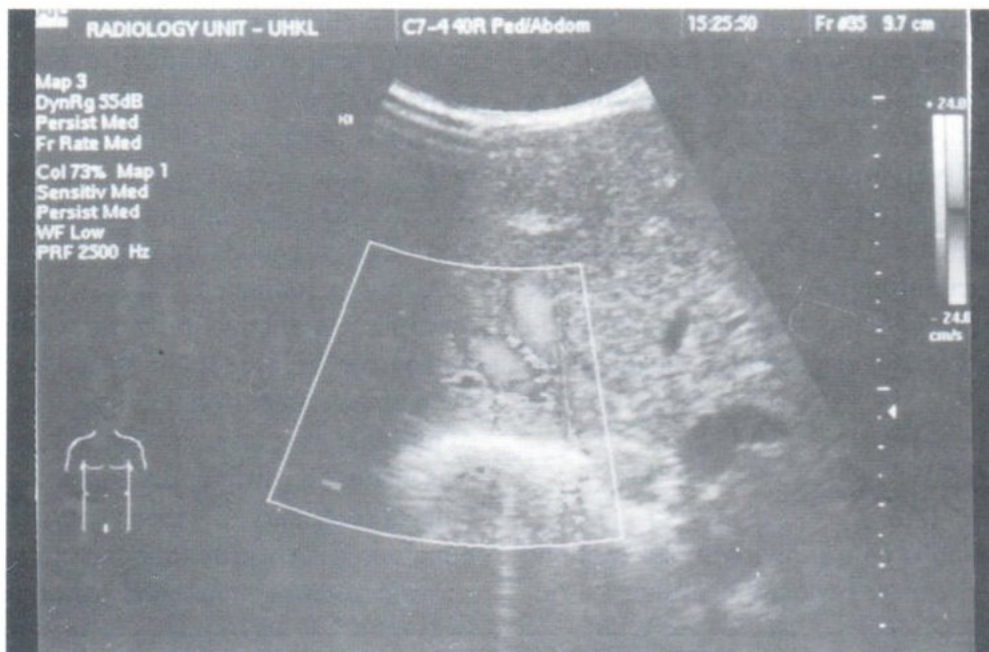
Doppler Ultrasound of the liver shows flow within the hepatic veins which are dilated but patent. The liver is of homogenous echogenicity.
